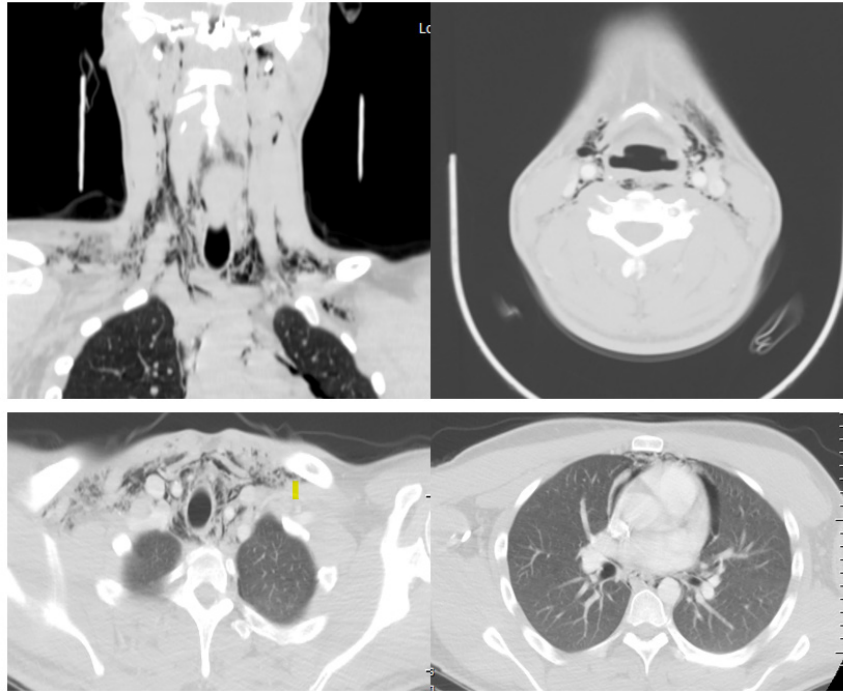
CT scan of the neck showed severe and massive soft tissue-subcutaneous emphysema with minimal pneumomediastinum.
